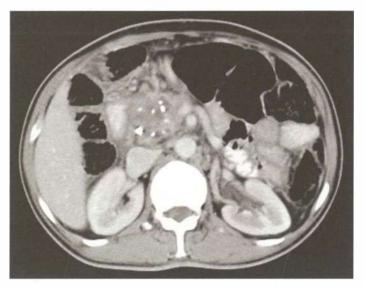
CT scan showing chronic pancreatitis with head mass. This case should be treated with head-coring operation
